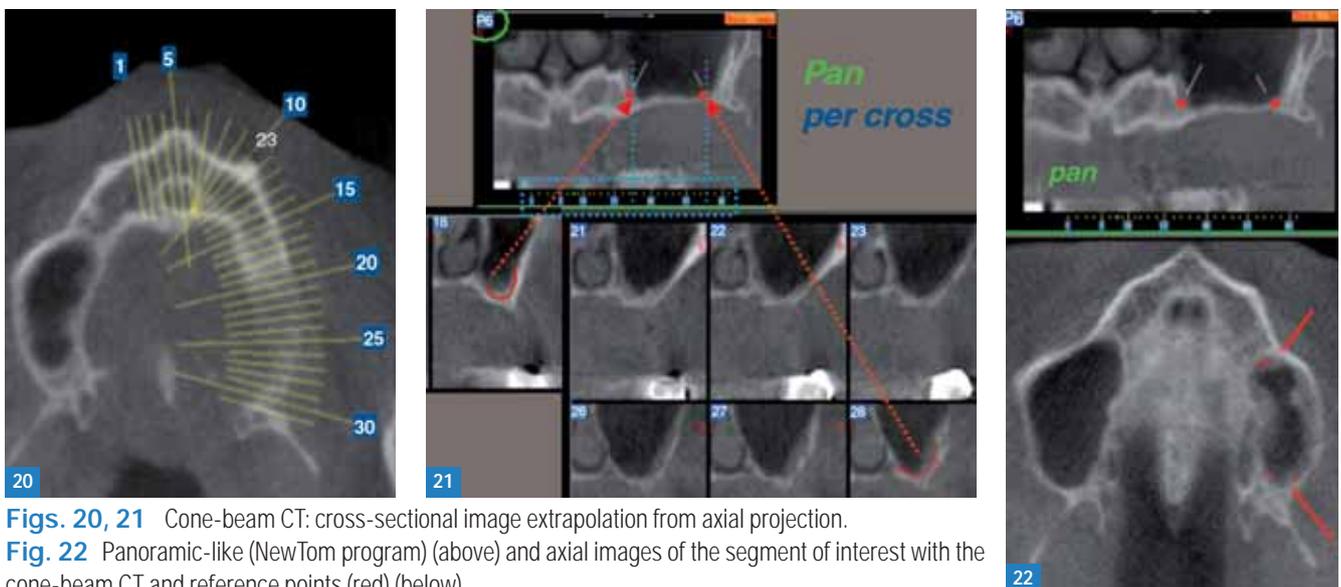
Cone-beam CT: axial reference.
